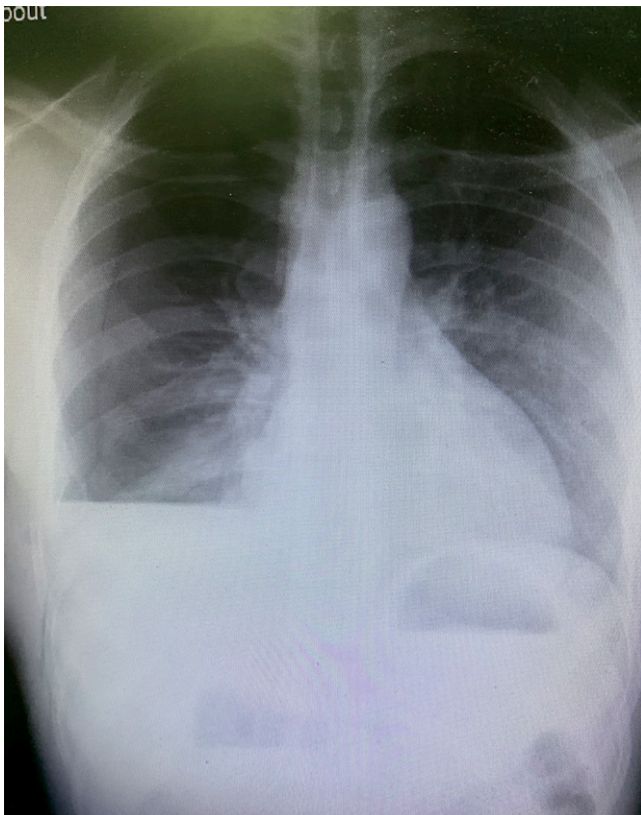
Chest X-ray showing a right hemothorax and an incomplete pneumothorax.
